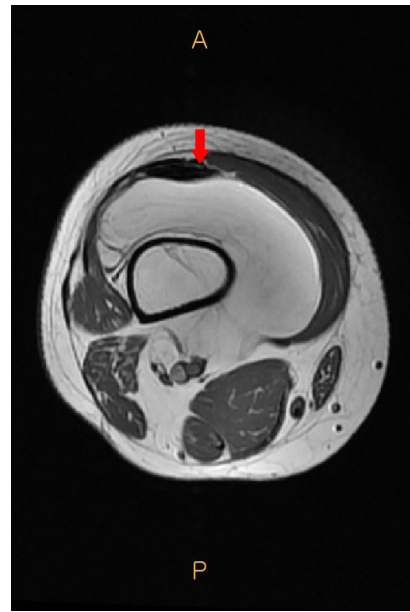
Preoperative contrast-enhanced magnetic resonance imaging (axial view) demonstrating a large lipomatous mass within the medial thigh surrounding the femur.
